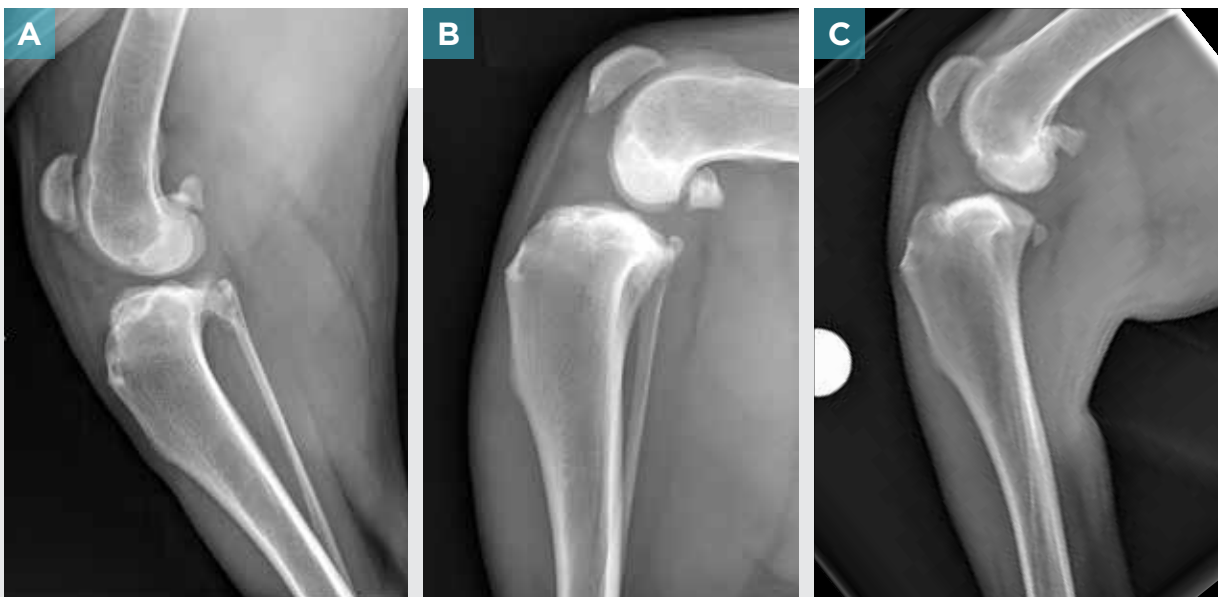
Three radiographs of the same patient with cranial cruciate ligament injury demonstrating rotational malposition of the tibia despite a straight femur. (A) The tibia is externally rotated. Note that more of the fibula can be seen and landmarks for tibial plateau angle measurement are difficult to identify. (B) The femur and tibia are positioned well. Note that a small amount of the fibula can be seen caudal to the tibia. (C) The tibia is internally rotated. Note that the fibula is hidden behind the tibia and the tibial condyles are not superimposed.
